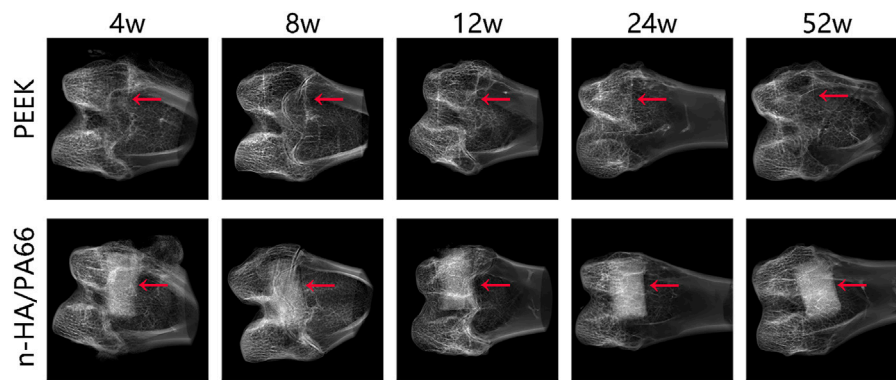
X-ray radiographs of the bone-implant interface with polyether-ether-ketone (PEEK) and nanohydroxyapatite/polyamide 66 (n-HA/PA66) implants at 4, 8, 12, 24, and 52 weeks. (red arrow: interface).
